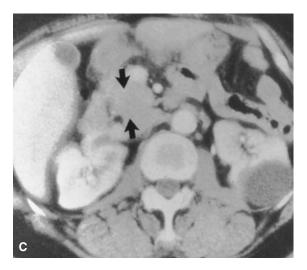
A*, This T₂-weighted magnetic resonance image demonstrates an insulinoma in a region of the pancreatic head (*arrow*). *B*, Preoperative sonogram demonstrates a small insulinoma. *C*, Axial contrast-enhanced computed tomographic scan demonstrates a hypervascular mass within the pancreatic head (*arrows*) that measured approximately 2.5 cm in diameter and produced mass effect on the superior mesenteric vein. Reproduced with permission from Buetow P. Islet tumors of the pancreas: clinical, radiologic and pathologic correlation in diagnosis and localization. Radiographics 1997;17:453–72. Copyright 1997 Radiologic Society of North America.
